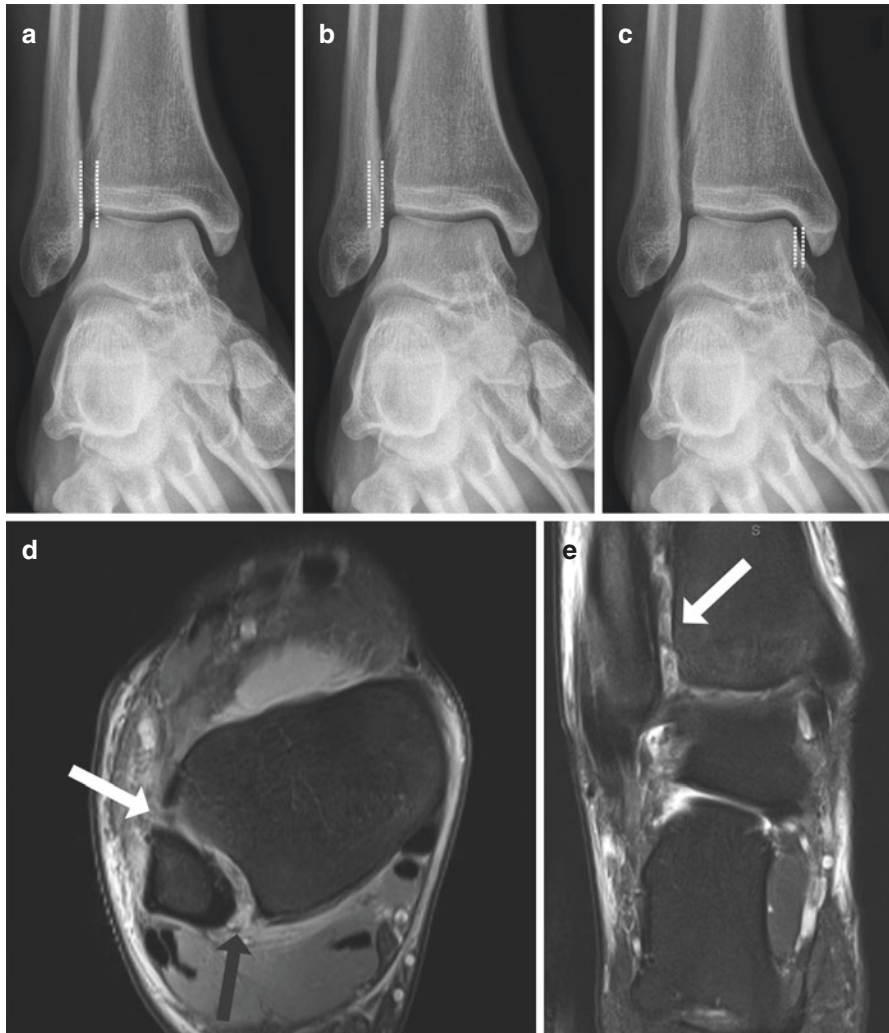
Example of a 37-year-old man with an acute isolated syndesmotism injury. The conventional radiographs (mortise view) cannot predict reliably the syndesmotism injury. (a) Normal tibiofibular clear space (TFCS). (b) Normal tibiofibular overlap (TFO). (c) Normal medial clear space (MCS). (d) Axial magnet resonance imaging (MRI) proton density with fat saturation demonstrates full-thickness tear of both the anterior (white arrow) and posterior (grey arrow) tibiofibular ligaments. (e) Coronal T2 fat-saturated MRI image shows heterogeneity and increased signal of the syndesmotism ligaments (arrow), consistent with syndesmotism injury [3]
